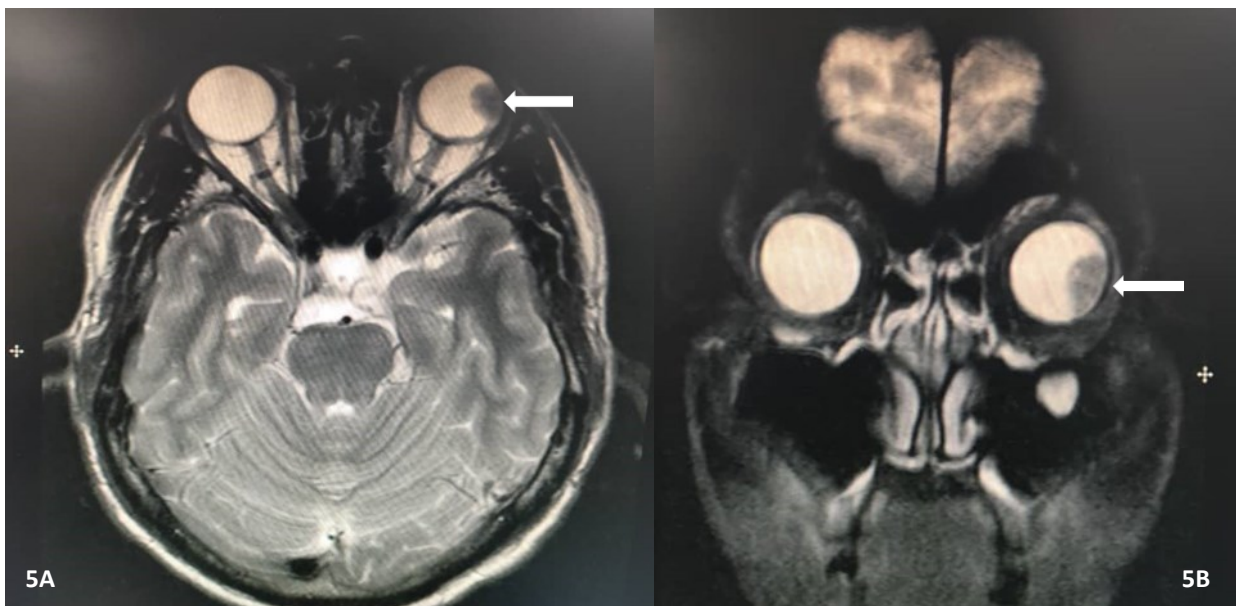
MRI of the orbit on axial view (5A) and (5B) coronal view T2-weighted image shows a well-defined intraocular lesion in the inferolateral aspect of the left eye (white arrow)
